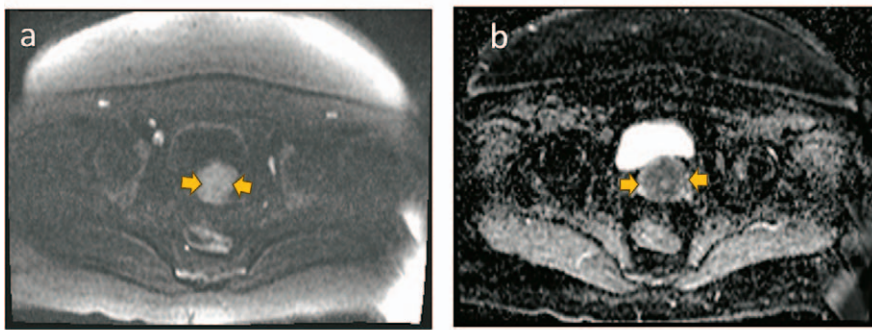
Axial diffusion-weighted image (DWI) (a), with the corresponding slice on the ADC map (b). The tumor is shown as a hyperintense mass (a, arrows toward tumor), corresponding to a hypointense mass on the ADC map (b, arrows toward tumor), a sign of proper diffusion restriction.
